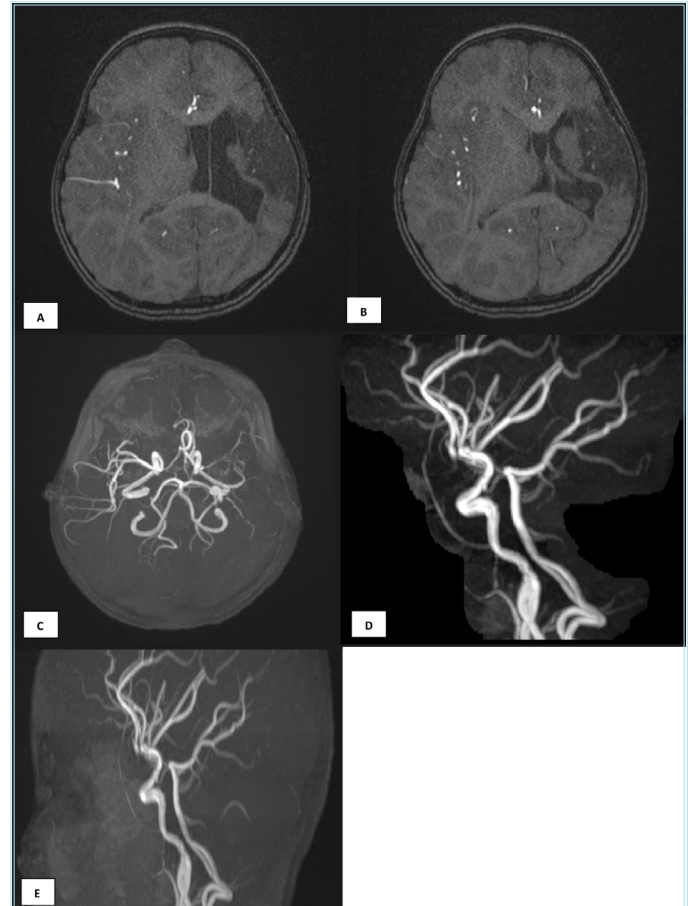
(A-E) MRI (3D-TOF) images in a 3-year-old child with chronic infarct showed encephalomalacic changes that follow CSF signal intensity on all sequences with surrounding gliosis involving the left fronto-parieto-temporal lobes, left thalamus, and basal ganglia. Ex-vacuo dilatation of ipsilateral lateral ventricle and prominent adjacent sulcal spaces are seen. Reconstructed images show hypointensities in the involved vessels. Features are likely suggestive of Wallerian degeneration, secondary to chronic infarct
